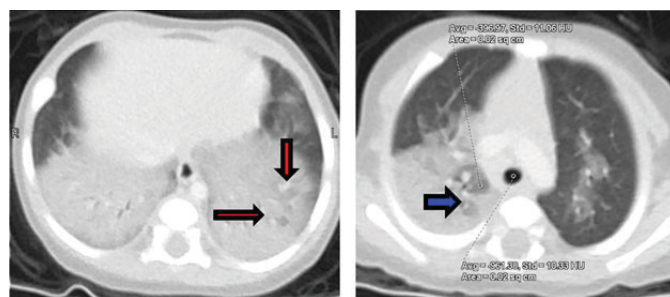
Chest CT scan showed bilateral lower lobe consolidation with patches of low attenuation (red arrows). Hounsfield (HU) of these areas averaged -397 with comparison to air, $HU = -961$ (blue arrow).
